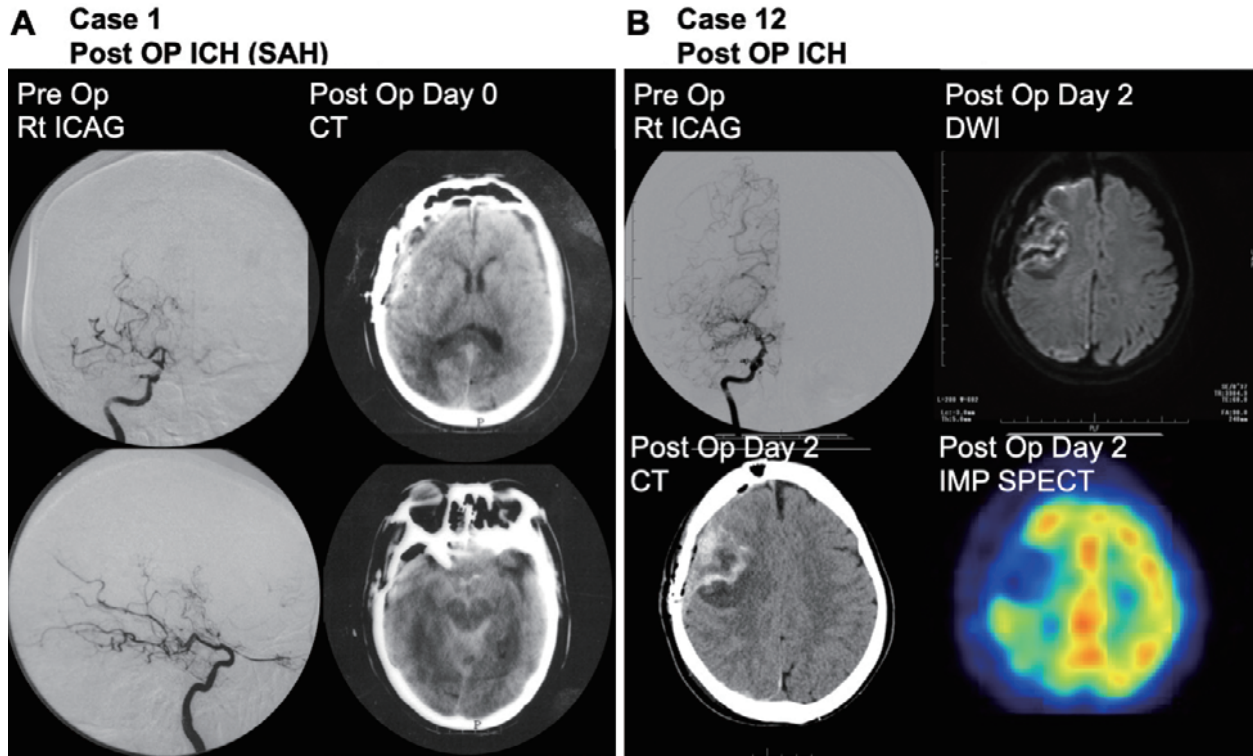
Pre and postoperative imaging of elderly patients with Moyamoya disease (MMD) who developed perioperative hemorrhagic complications. (A) Case 1, 68-year-old man with MMD with right parietal lobe infarct. Pre-operative cerebral angiograms showing occlusion at the terminal portion of the right internal carotid artery with minimization of basal moyamoya and increase of ethmoid moyamoya vessels (Suzuki's angiographical stage 4). Postoperative head CT scan depicted subarachnoid hemorrhage in the right sylvian and basal cistern and thin subdural hematoma at the site of anastomosis. (B) Case 12, 60-year-old woman with MMD with right temporal lobe old hemorrhage. Cerebral angiogram showing severe stenosis at the terminal portion of the right internal carotid artery with marked development of basal moyamoya vessels (Suzuki's angiographical stage 3). Postoperative head CT scan depicted intracerebral hematoma in the right frontal lobe where superficial temporal artery - middle cerebral artery anastomosis was performed. Diffusion weighted image showed no acute cerebral infarct around the hematoma. Also, ^{123}I -IMP SPECT depicted hypoperfusion at the site of hematoma.
